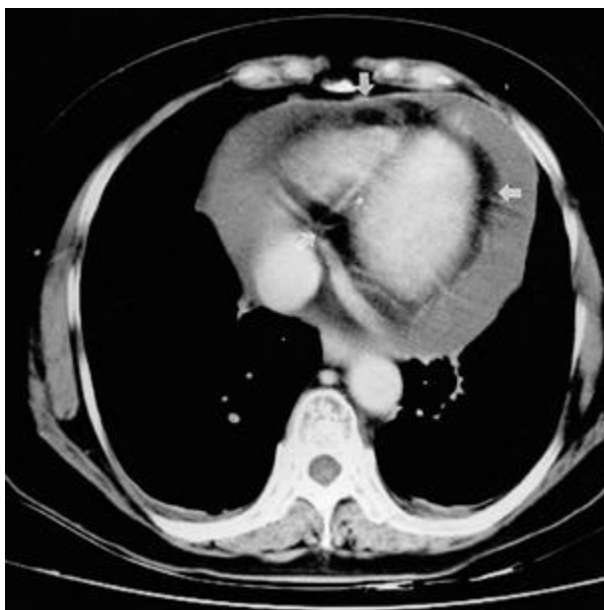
Chest CT revealed a thickened low attenuated band-like area along the large amount of pericardial effusion, suggesting prominent fat tissue. Mass lesions were absent.
